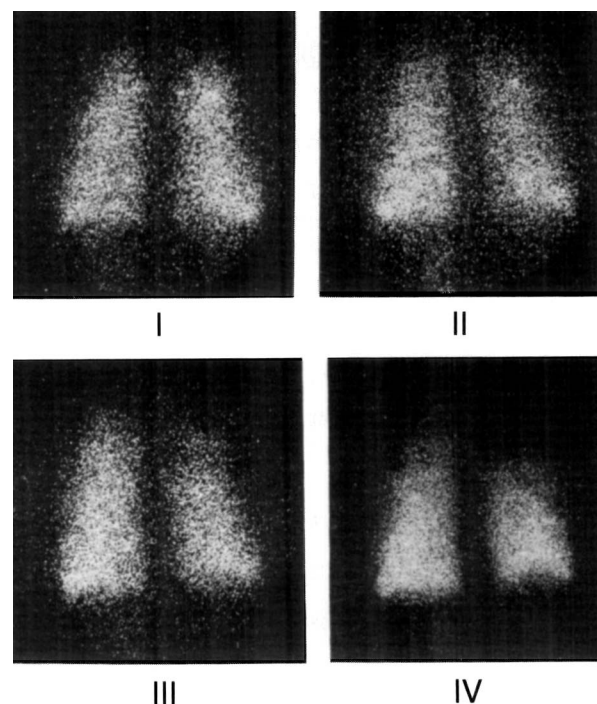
Example of ventilation scintigrams (posterior acquisition) obtained at examination I-IV. Three months after the irradiation there was a ventilation defect at the right apex. This persisted one year after the irradiation. I: Before irradiation. II: At termination of irradiation therapy. III: Three months after irradiation. IV: One year after irradiation.
